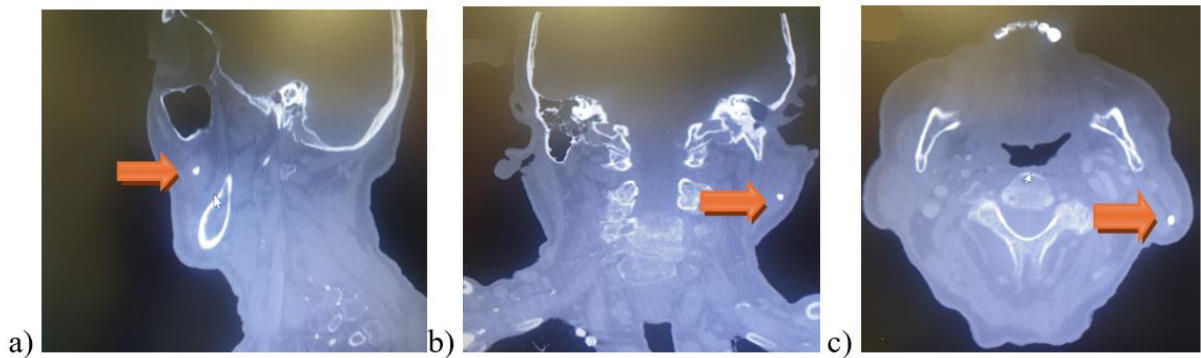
Sagittal, axial, and coronal CT images show a radiopaque sialolith measuring approximately 10 mm x 6 mm
